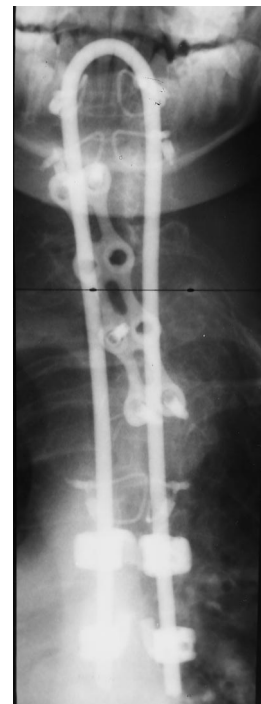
Case 2. Postoperative anteroposterior radiograph of the cervicothoracic spine.
